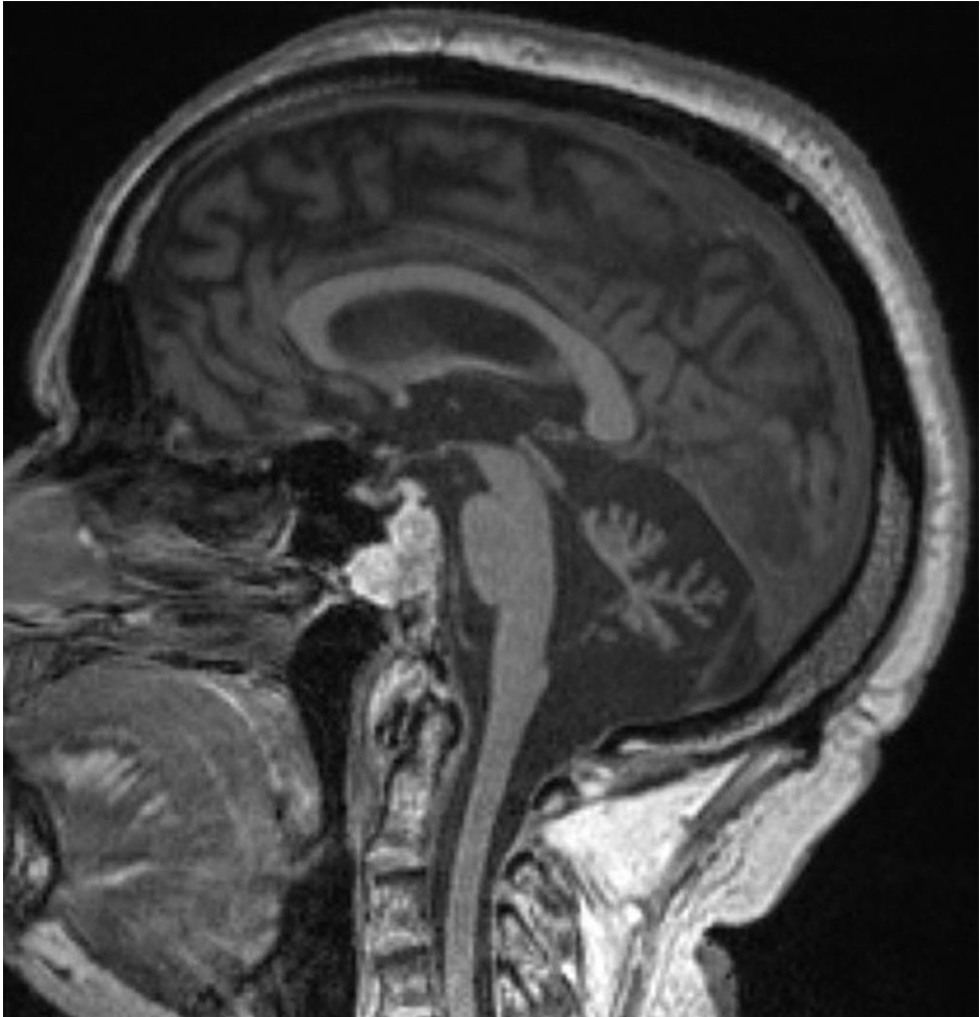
Sagittal MRI of one of our patients with ataxia-pancytopenia syndrome showing atrophy of the cerebellum and the brainstem.
